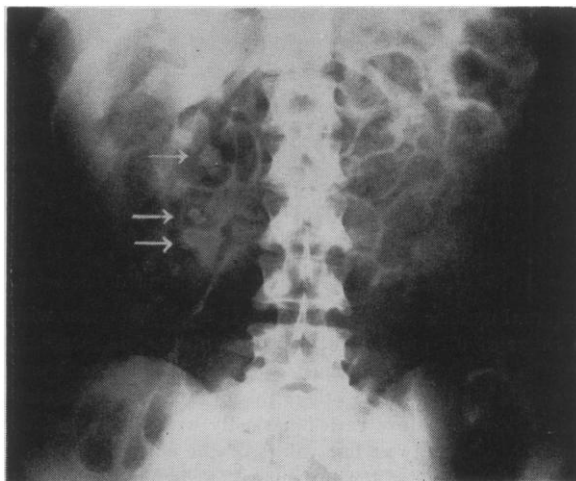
The arrows on the roentgenogram point to the stones in the right kidney pelvis in the patient C. G., none being present in the left kidney.
